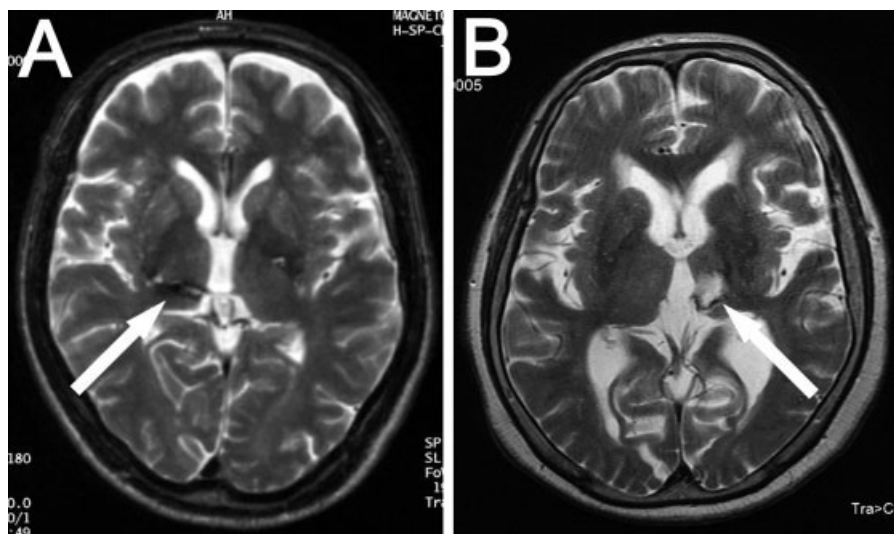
Magnetic resonance images obtained at admission. (A) Case 1. (B) Case 2. Arrows indicate scar lesions in the medial to posterior portion of the thalamus. Thalamic atrophy is apparent in both cases.
